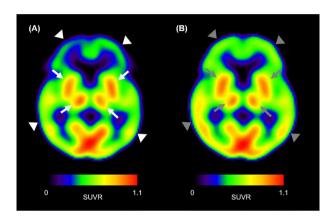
Representative images of early-phase PETs. The ¹⁸F-FP-CIT SUVR image showed less uptake in cortical areas (white arrowheads in A) than the ¹⁸F-flutemetamol SUVR image (grey arrowheads in B), while the central structures showed similar activity in the two PETs (white arrows in A and grey arrows in B).
